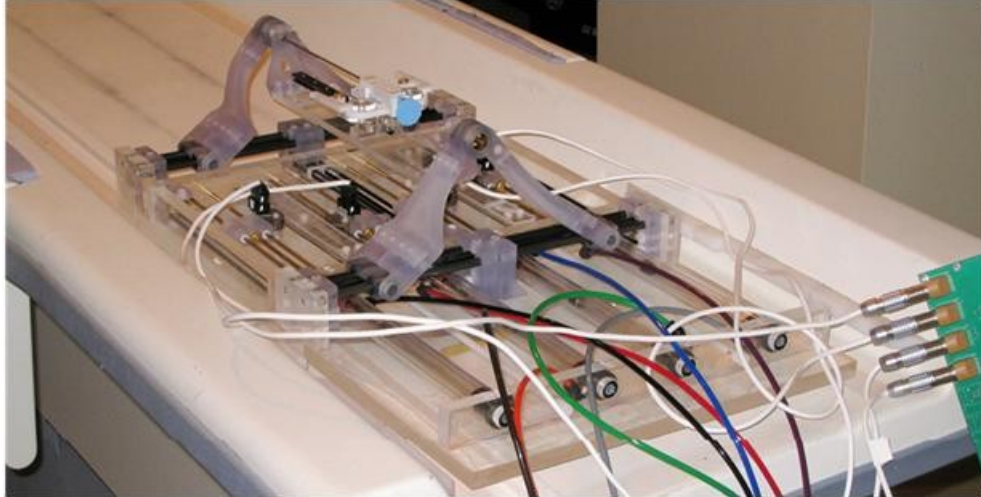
Pneumatically operated MRI-guided prostate biopsy mechanism. The coloured tubes supply air to four horizontal cylinders at the base of the mechanism [Song, 2010].
